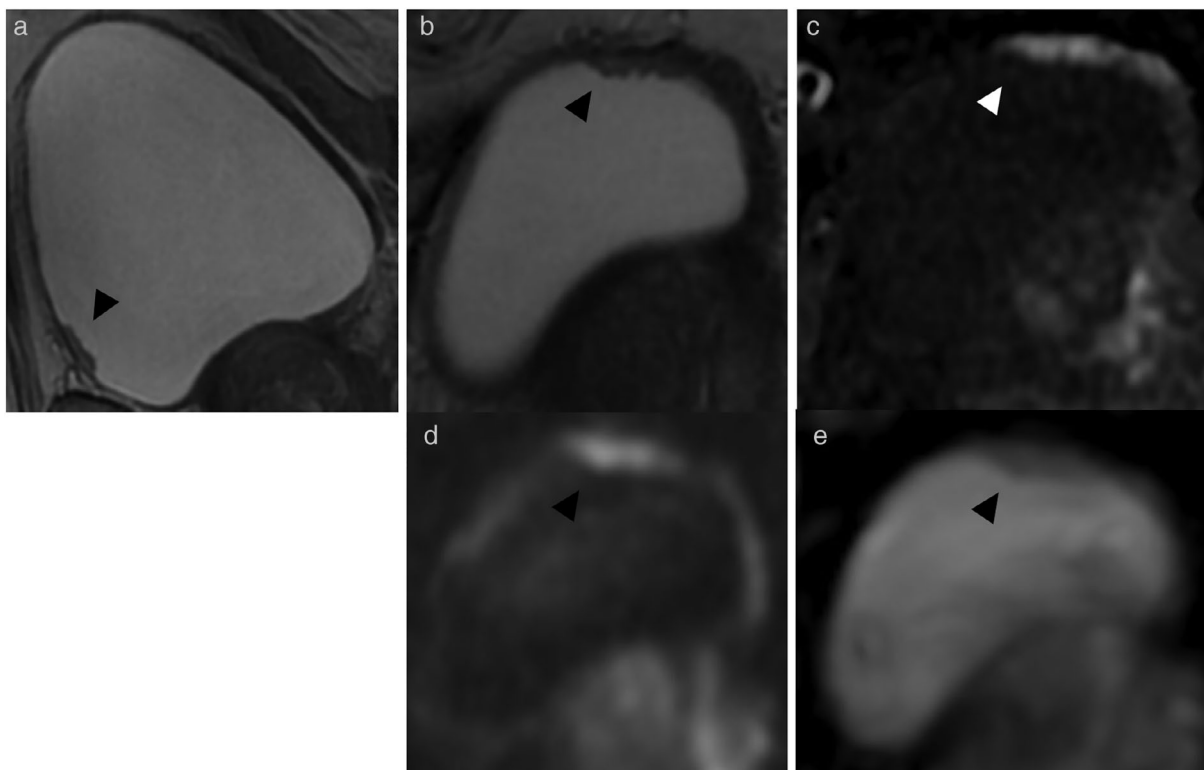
A 75-year-old male treated with TURB for NMIBC. (a,b) T₂W imaging (sagittal, axial plane) shows a sessile mass >1 cm in size (arrowhead) at the level of the anterior bladder wall, with intermediate SI that does not extend through the muscularis propria. T₂W imaging assigned as VIRADS category 2. (c) DCE imaging shows early and heterogeneous enhancement of the lesion, not clearly extending through the muscularis propria. DCE assigned as VI-RADS category 3. (d,e) DWI (b = 2000) and ADC maps show a lesion with significant restricted diffusion, not clearly extending through the muscularis propria. DWI assigned as VIRADS category 3. Overall VI-RADS score was 3.
